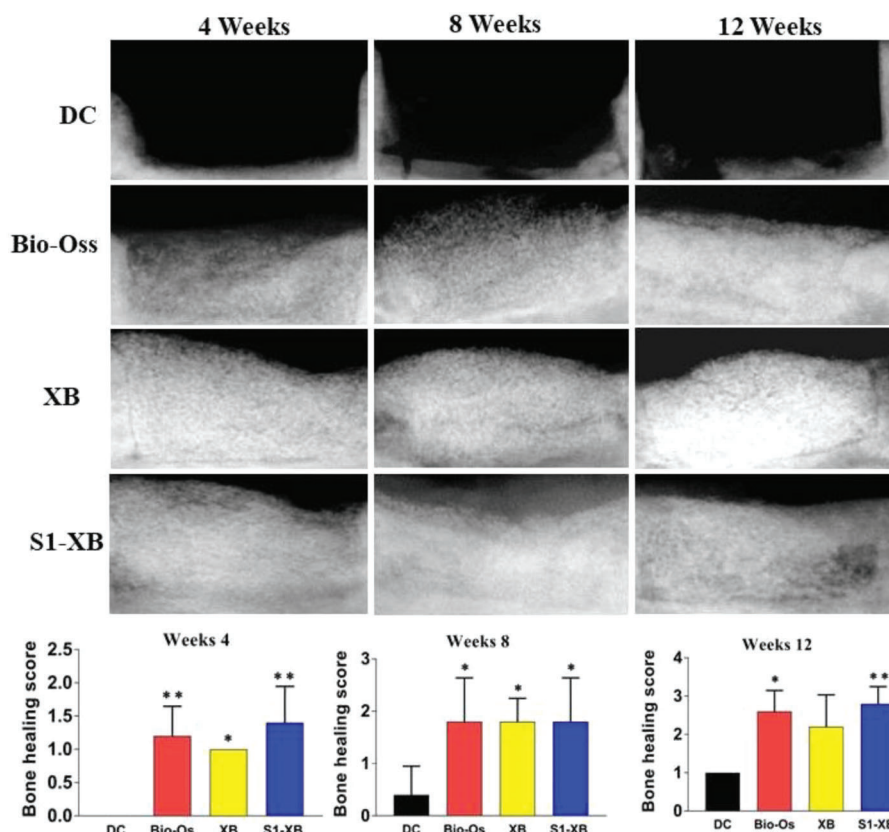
Radiographic evaluation of bone healing.
